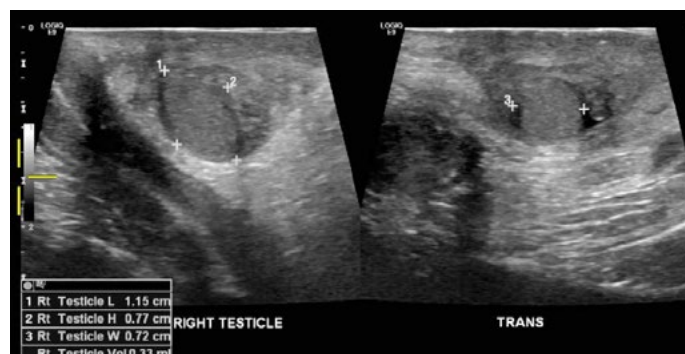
Scrotal ultrasound of right testicle showing the position and measurements
